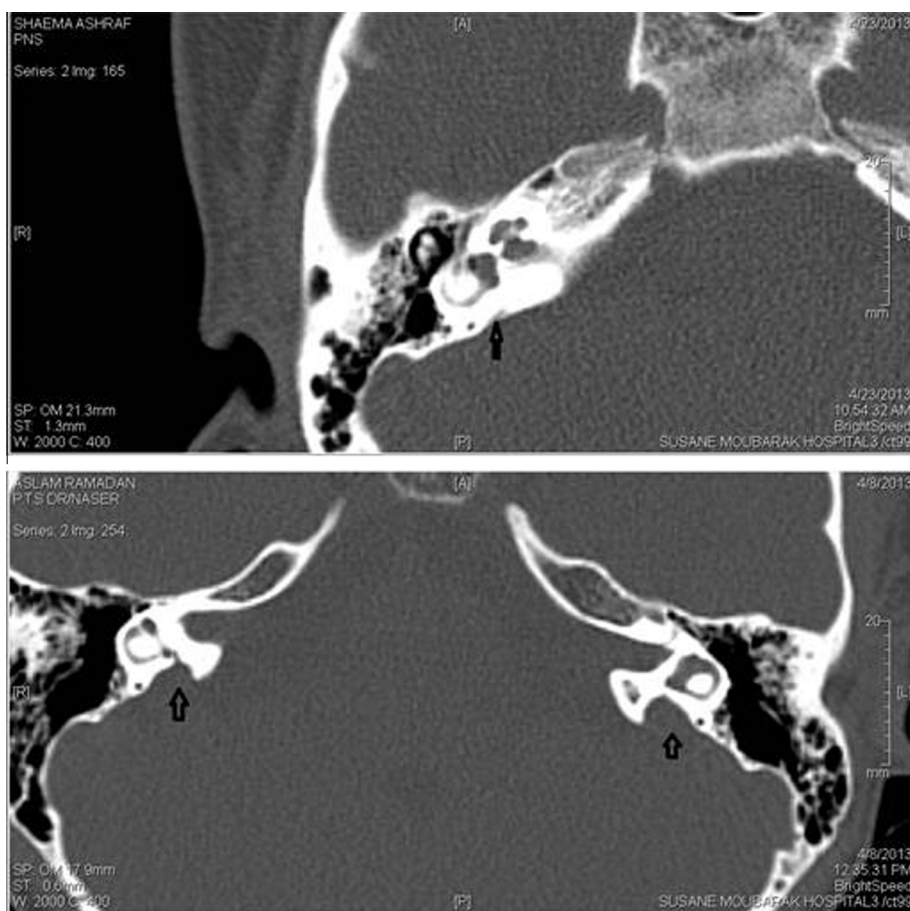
MDCT scan (axial CT section). Upper image (axial epitympanic level) shows normal VA and lower image (axial LSC level) shows LVA (arrows point to VA).
